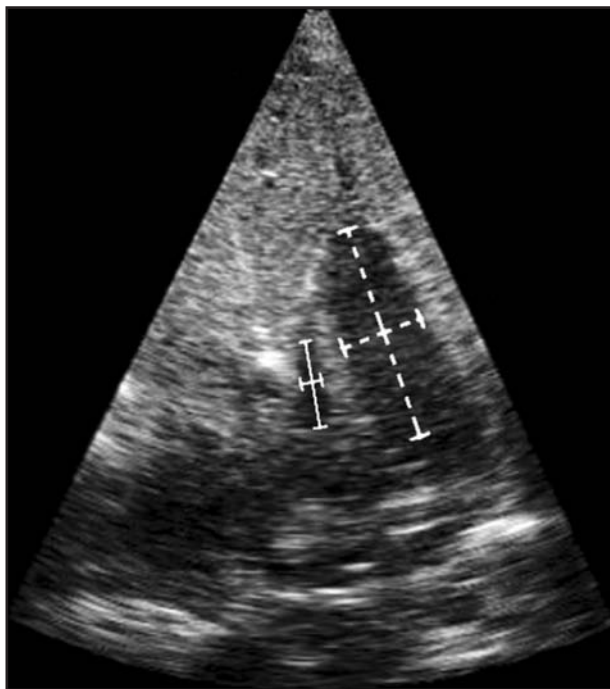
Transcoelomic echocardiographic horizontal view of the heart of a red-tailed hawk (*Buteo jamaicensis*) in diastole, as obtained through a ventromedian approach to transducer probe placement (frame rate, 225 Hz; depth, 4 cm). Measurement lines are shown within the left ventricle (dashed lines) and right ventricle (solid lines).
